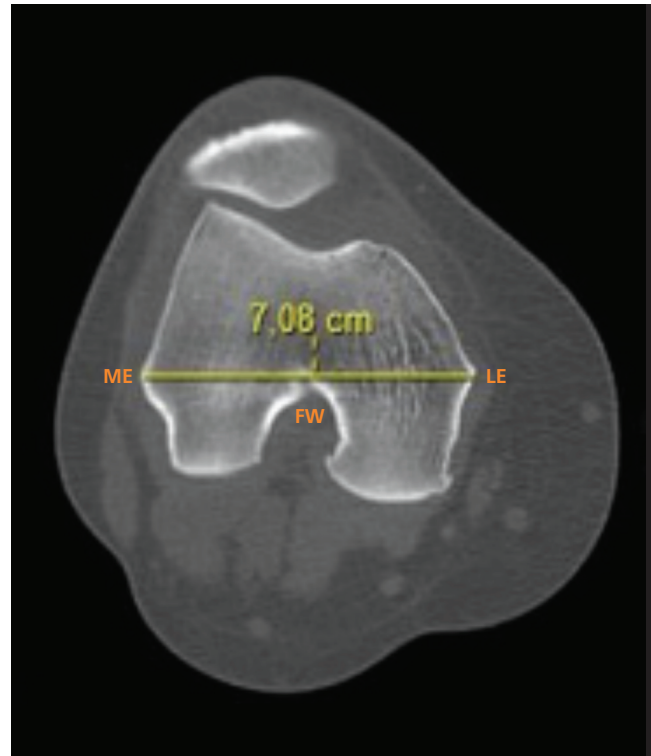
Axial CT image. Femoral transepicondylar width (FW) is the distance between the most prominent point of medial femoral epicondyle (ME) and the most prominent point of the lateral femoral epicondyle (LE).
